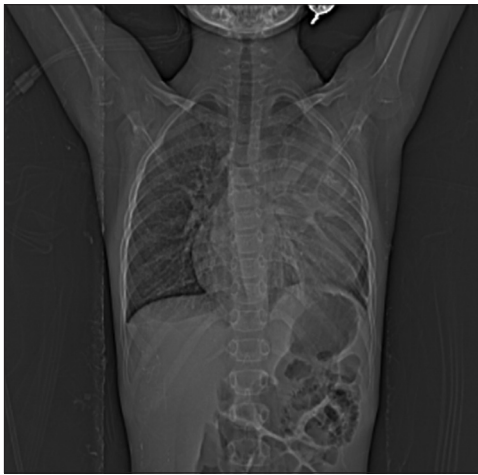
Preoperative chest X-ray showing homogenous opacity in mediastinum
